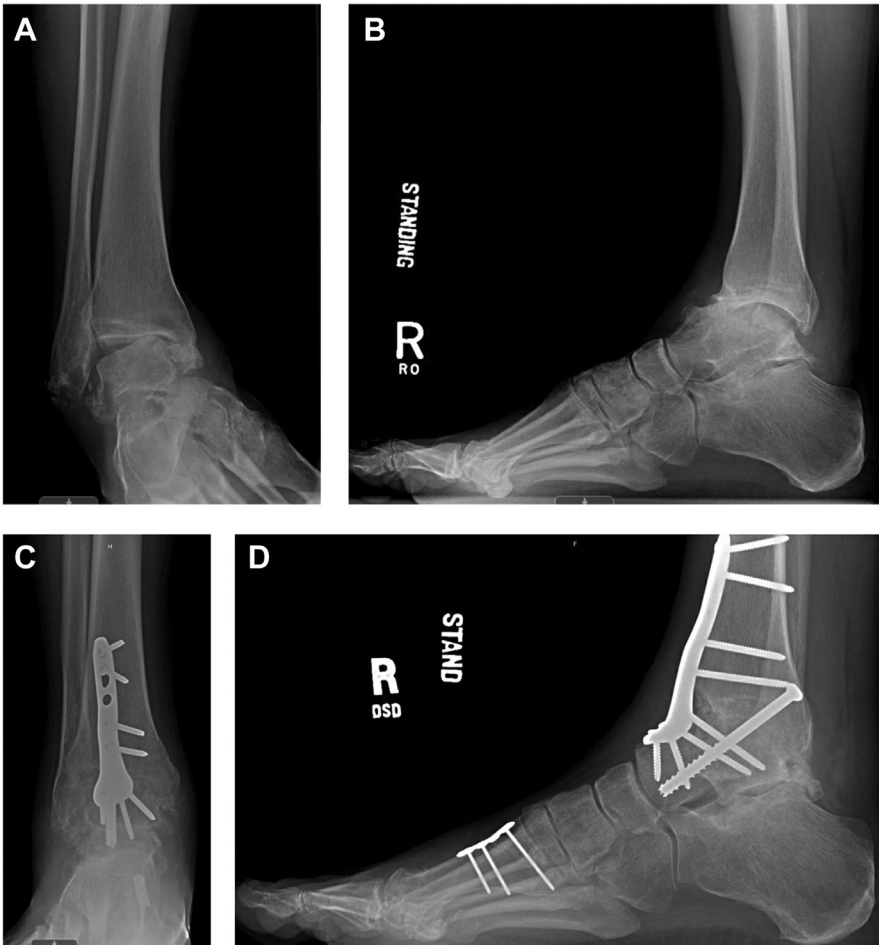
(A, B) Preoperative radiographs showing varus ankle arthritis with associated anterior translation of the talus. (C, D) 6-months postoperative radiographs showing anterior plate and lag screw construct correcting both deformities.
